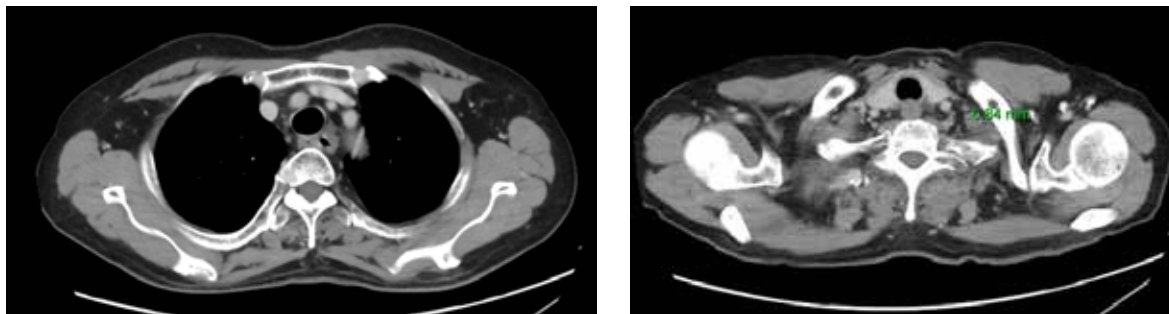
CT scan 1 month after concurrent chemoradiotherapy
